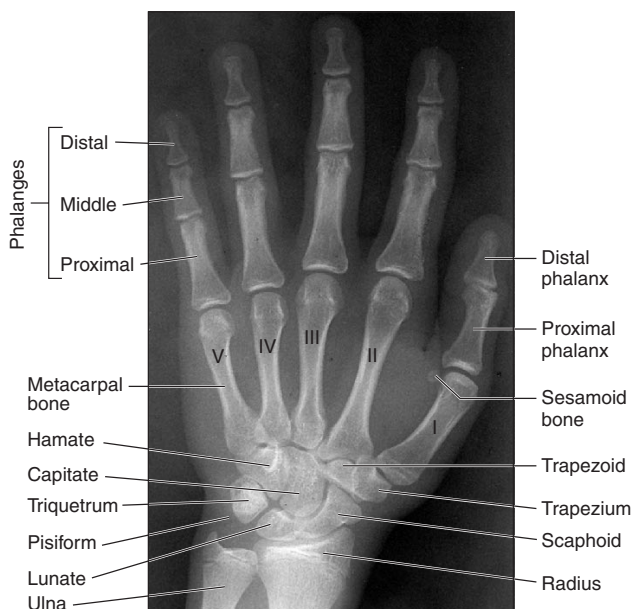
A radiograph of the right hand shown in an antero-posterior projection. (Note the presence of a sesamoid bone at the thumb joint.)
